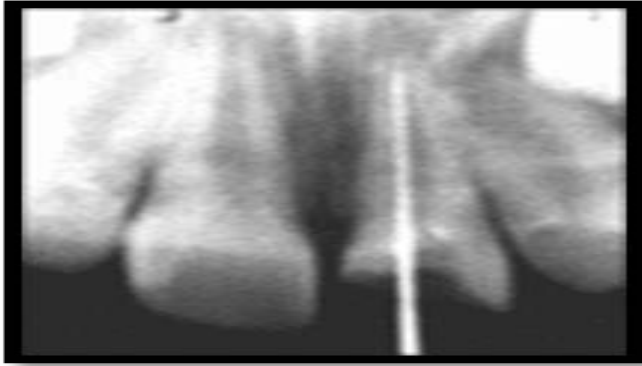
Periapical radiograph taken after 3 months shows confirmation of apical barrier with gutta-percha point
